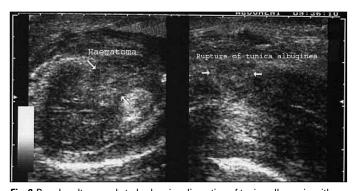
Doppler ultrasound study showing disruption of tunica albugenia with intracavernosal hematoma (marked by arrows).
